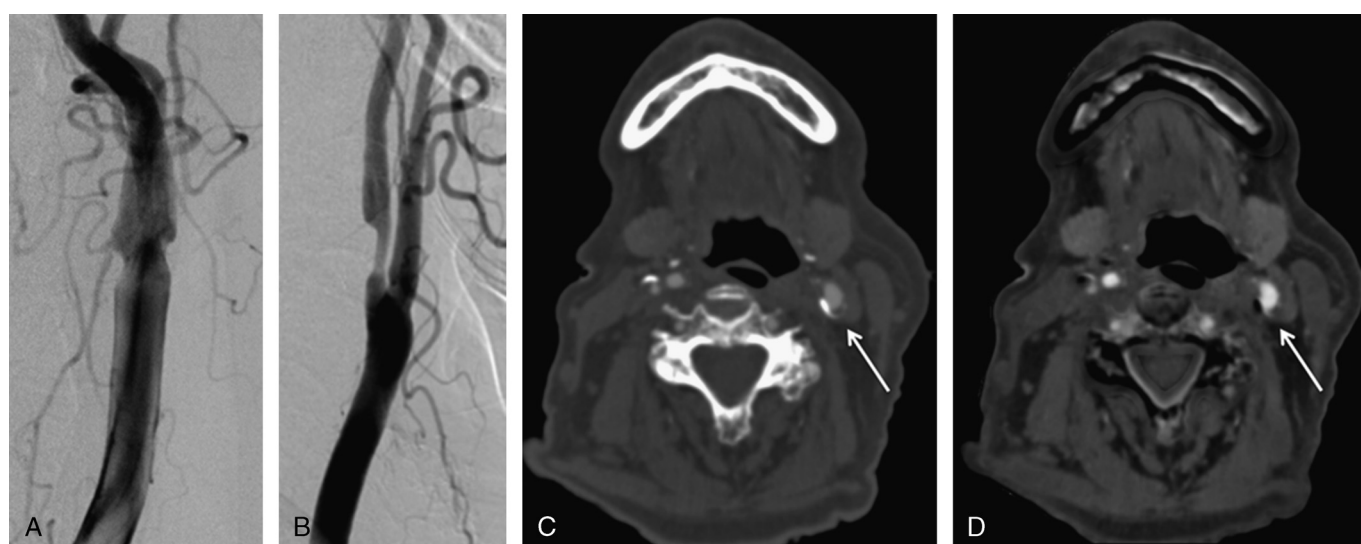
A 78-year-old woman with mixed plaque stenosis (59%) of the left internal carotid artery. A and B, Digital subtraction angiography in coronal and sagittal projection. C and D, Axial mean computed tomography angiography (left) versus axial virtual noncalcium imaging (right) at the location of maximum calcified carotid artery stenosis (arrow).
